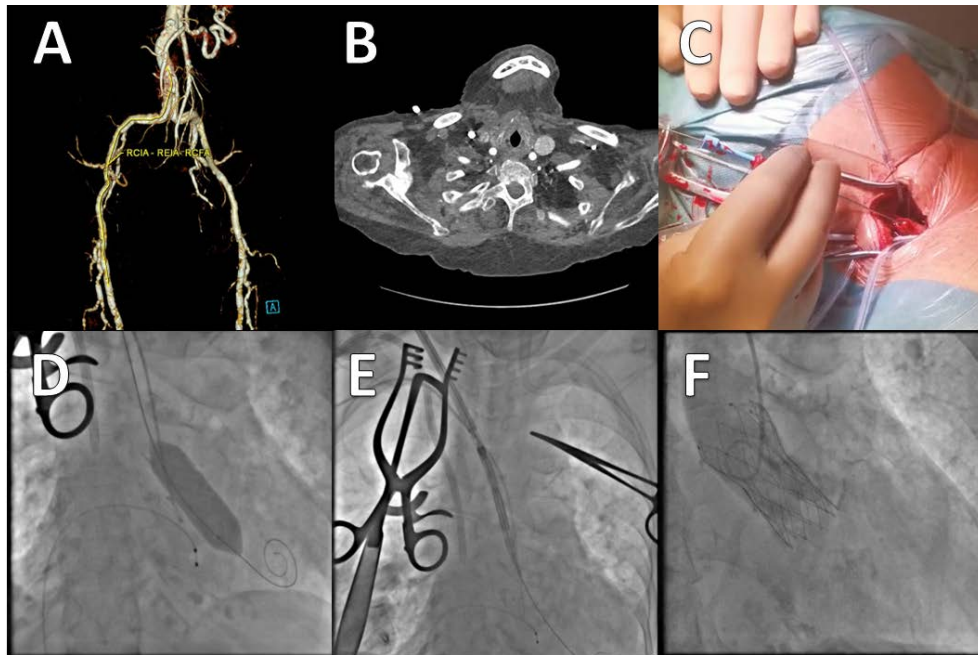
A. Computed tomography angiography with 3D reconstruction, diffuse calcifications of stenotic iliac and femoral arteries making the patient not suitable for transfemoral transcatheter aortic valve implantation (TAVI). B. Computed tomography angiography of the carotid vessels confirming appropriate vessel size and lack of significant plaques within right common carotid artery. C. Transcarotid access for TAVI procedure. D. Transcarotid access — balloon aortic valvuloplasty. E. Transcarotid access — valve delivery and positioning. F. Transcatheter aortic valve implantation — transcatheter heart valve successfully deployed
